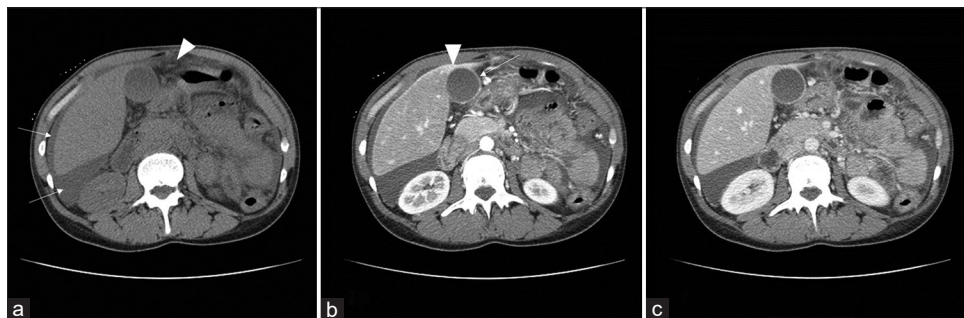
(a) Axial nonenhanced computed tomography scan reveals perihepatic fluid effusion (white arrows) and omental hyperattenuation (arrowhead); (b) Axial arterial phase contrast-enhanced computed tomography scan reveals enhancement of the Glisson's capsule on the left hepatic segments (arrowhead) and of the gall bladder walls (white arrow); (c) Axial portal-venous phase contrast-enhanced computed tomography scan confirmed the findings showed in Figure 1b
